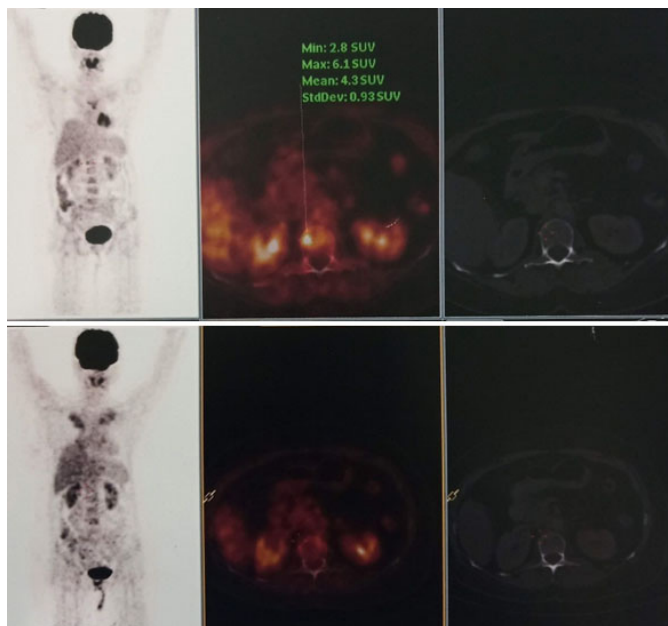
PET-CT (April 2018) showing active hypermetabolic lytic lesion in the L1 vertebra (SUV_{max} 6.1).
